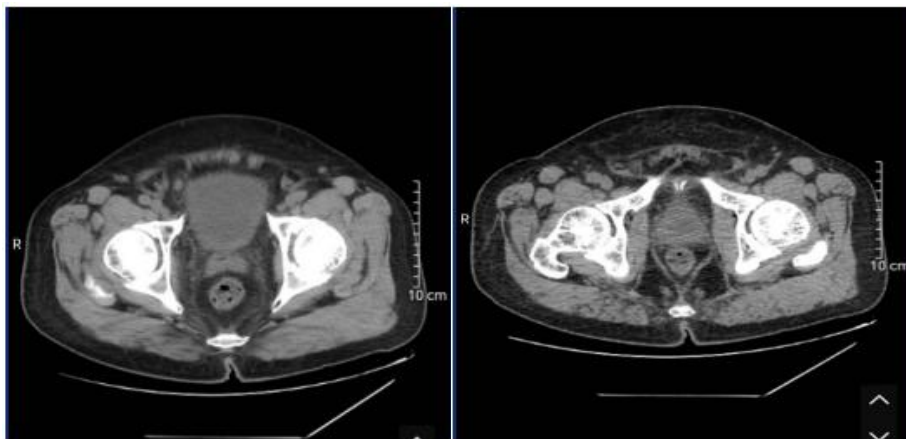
CT scan results indicating prostate hyperplasia.
